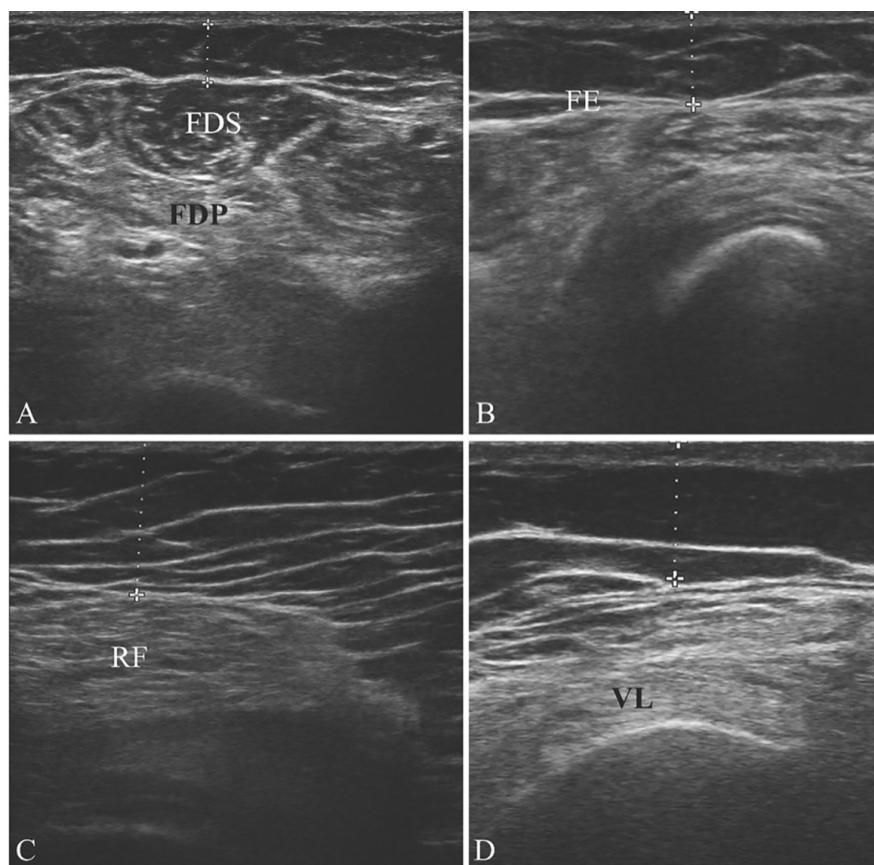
Muscle ultrasound in an IBM patient.
